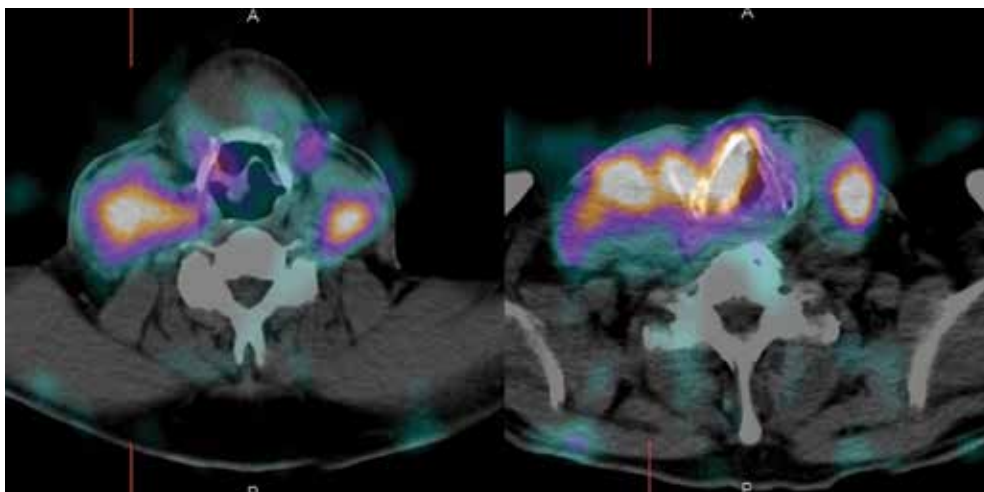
A 61-year-old male with NEC of laryngopharynx (case number 5). ^{99m}Tc -EDDA/HYNIC-TOC SPECT/CT showed intensive uptake in neck lymph nodes (bilateral) and in primary tumor of laryngopharynx. NEC, neuroendocrine carcinoma; SPECT/CT, single photon emission computed tomography/computed tomography
